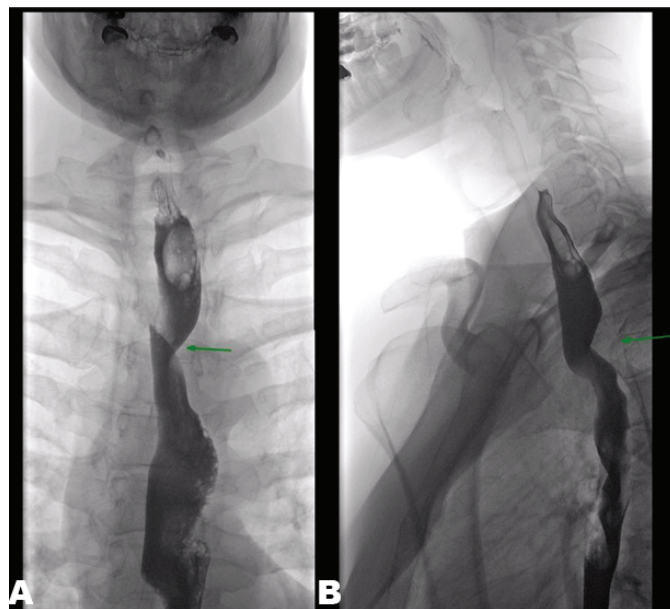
(A and B): Anterior and lateral views of a barium swallow examination displayed on radiographs. Barium causes substantial attenuation of X-rays and so allows the visualisation of the oesophagus after it has been swallowed. The image on the left is an anterior view of the barium swallow examination with a green arrow marking the indentation on the oesophagus by the right subclavian artery. The image on the right is a lateral view of the barium swallow examination with a green arrow marking the indentation on the oesophagus by the right subclavian artery.
